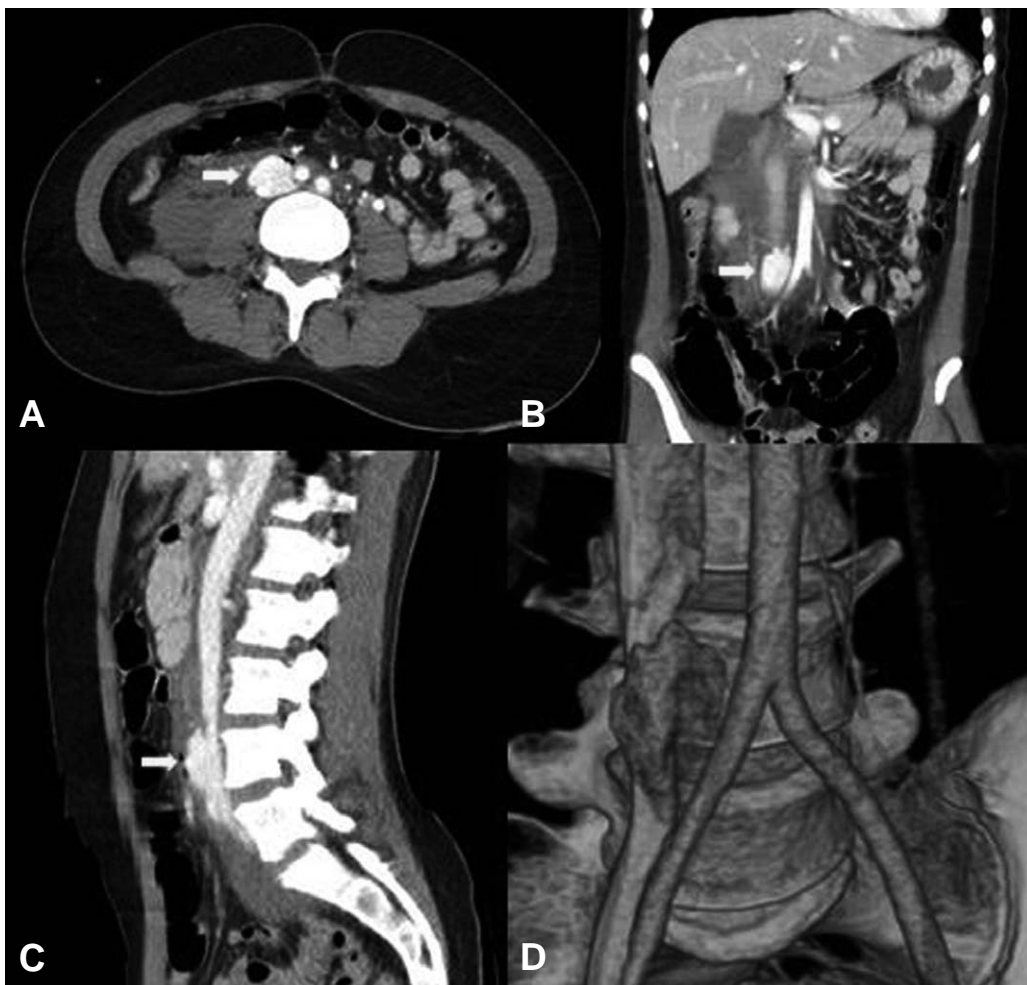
Computed tomography showed laceration of infrarenal IVC with active bleeding (arrow).
